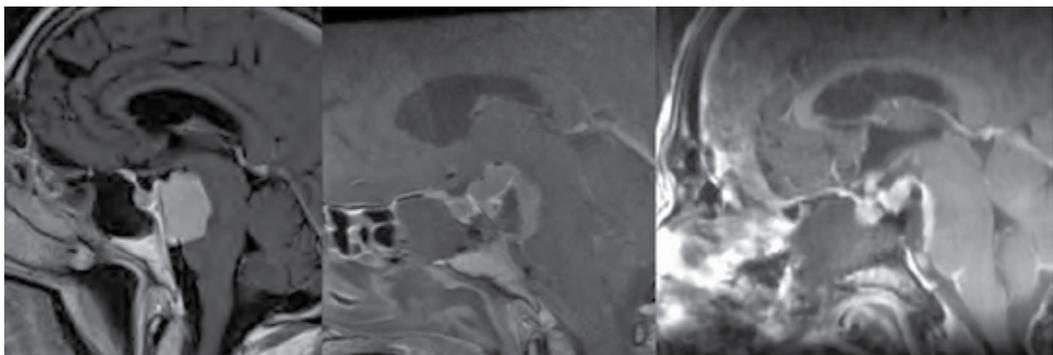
Sagittal T1-weighted post contrast preoperative, first intraoperative and second intraoperative MRI in 78 year old myelopathic gentleman with clival meningioma with significant brainstem compression. The surgical goal was to debulk the lesion leaving a small capsule however endoscopically it was difficult to determine how much residual tumor persisted behind the pituitary gland which is clearly seen on the middle image. On the final image the capsule can be seen falling away from the diencephalon and chiasmatic region.
